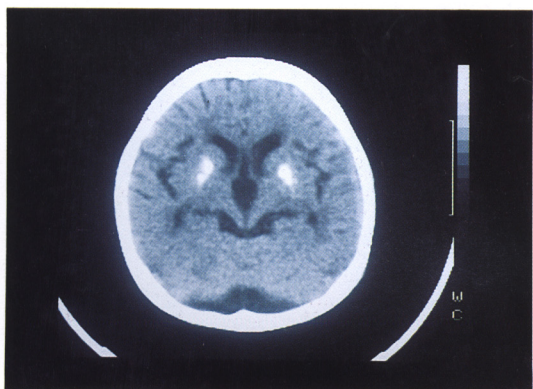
Cranial CT reveals mild ventricular dilatation and dense calcification in the basal ganglia.
